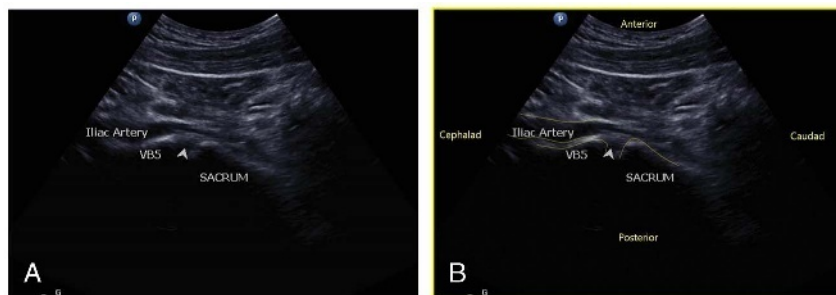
Longitudinal sonographic image showing the lumbar 5 vertebral body (VB5), L5–S1 disc (arrowhead) and the sacrum.
